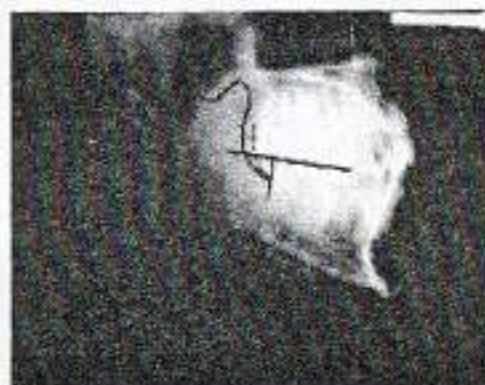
Analysis of computerized radiograph
